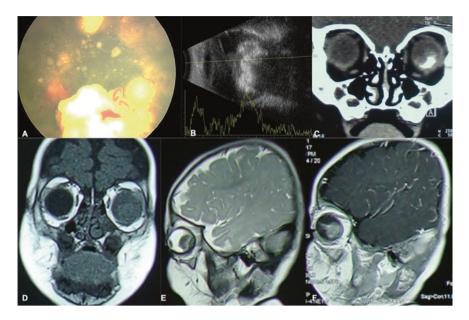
a, b Mixed (endophytic and exophytic) large calcified retinoblastoma tumor with severe and extensive vitreous seeds. c The computerized scan showed the calcified mass. d, e Magnetic resonance imaging showed the higher than vitreous reflectivity on T1, lower reflectivity on T2 and enhancing of the lesion after injecting the contrast
